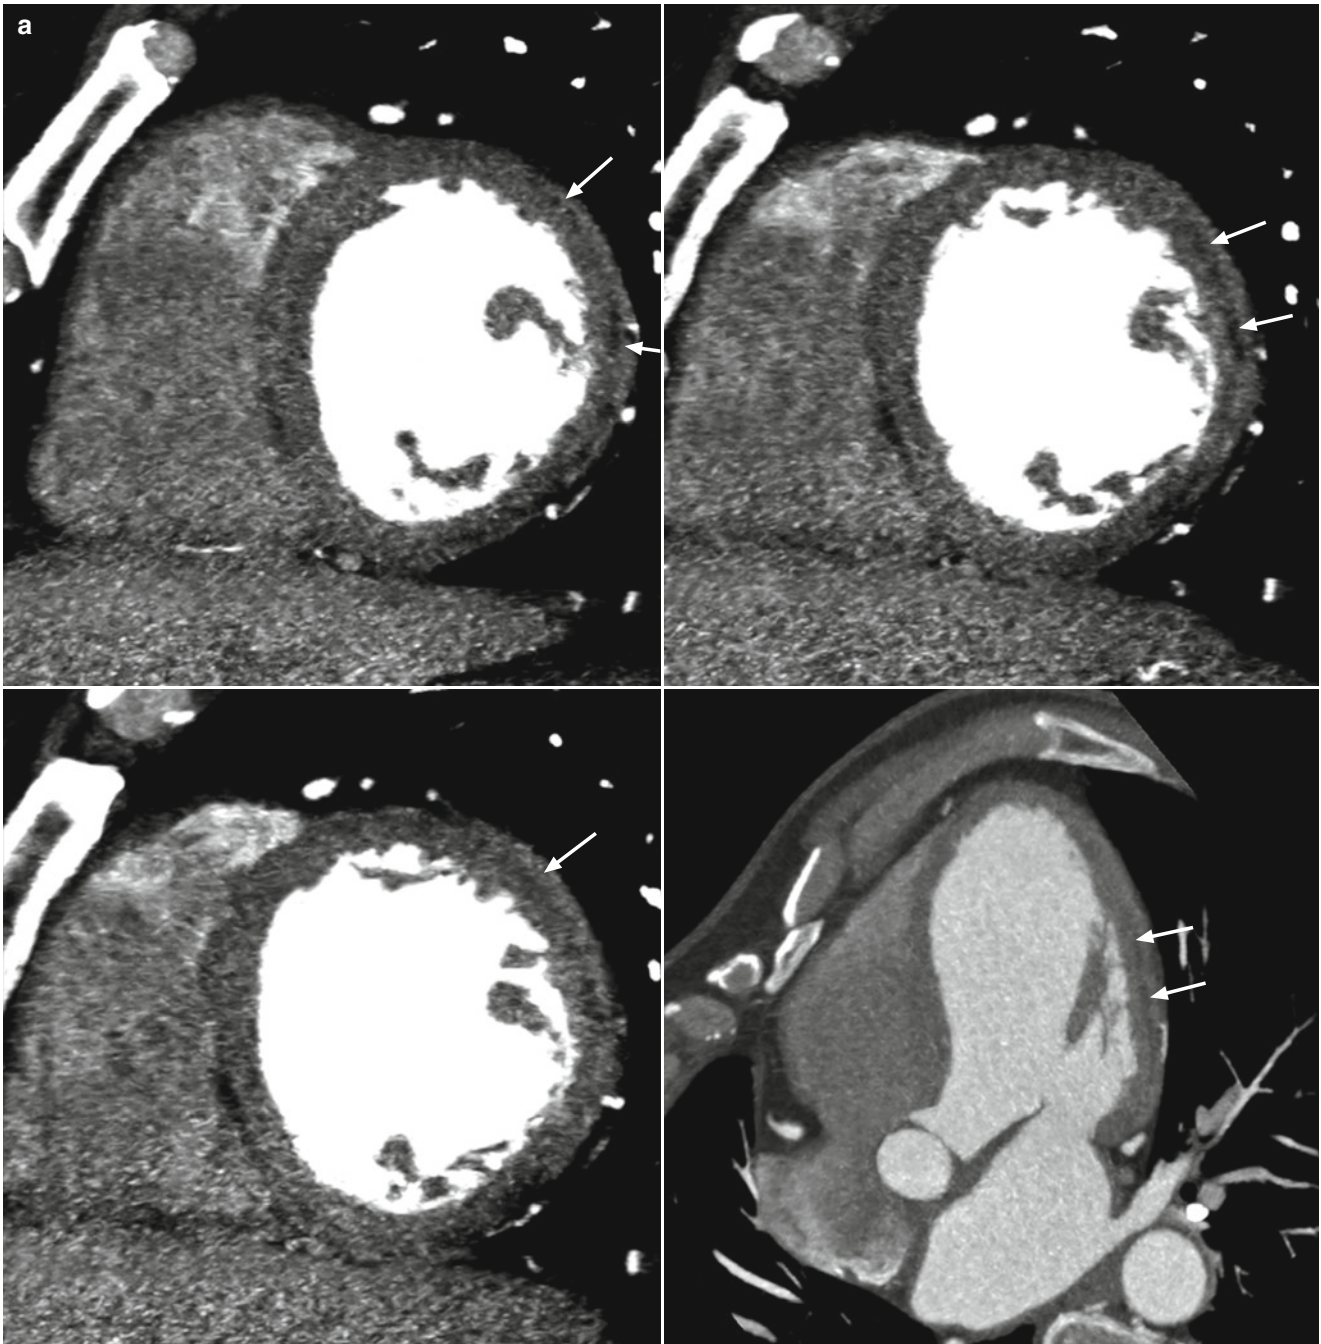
Cardiac involvement in a patient with Behçet's disease. (a) CT and (b) late gadolinium enhancement MR image show areas of fibrosis and fat infiltration (*arrows*) in the mid-layer of the left ventricle
